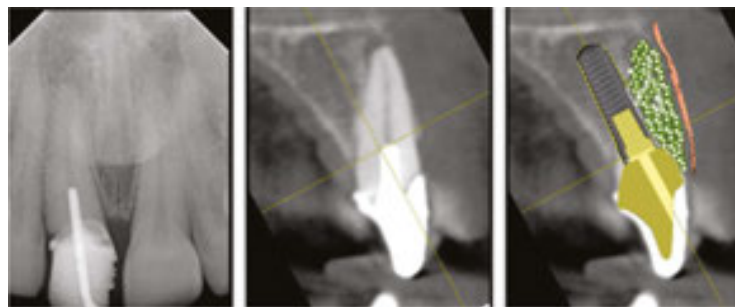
The cross-sectional CBCT cut showed that the tooth had little or no labial bone plate, but that there was a good volume of stable bone in the palatal wall of the socket. The principle of the procedure then is to anchor an implant into this palatal wall. The empty bone socket then needed to be filled with a bone graft and the outer wall of the socket needed to be protected with a membrane.
